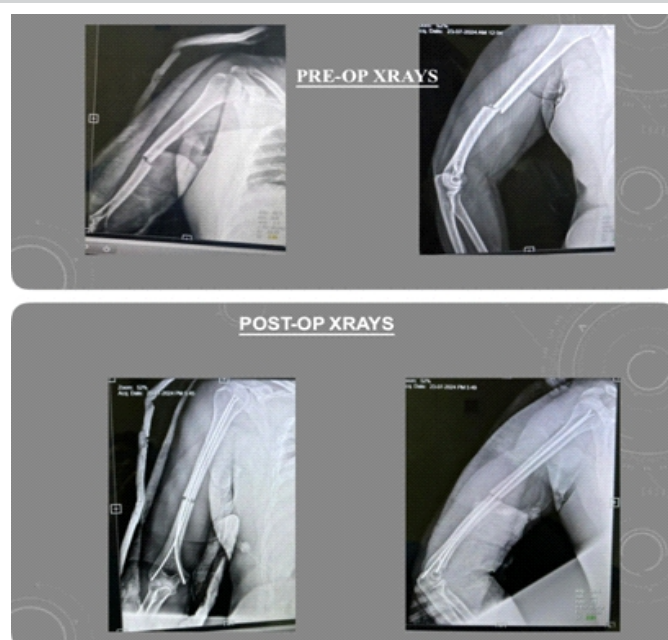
(a and b) Pre-operative and post-operative radiographs – Case 5.
